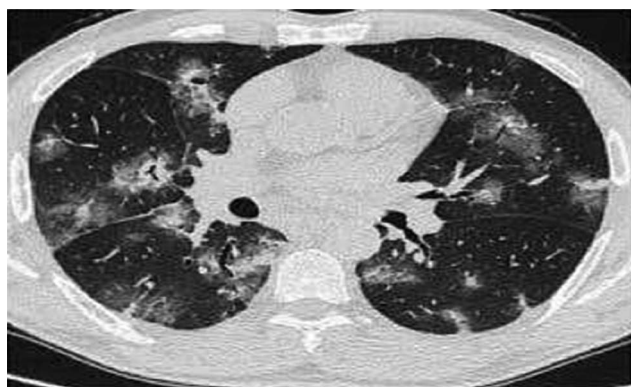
Computed tomography revealed mild pulmonary infiltrations.
